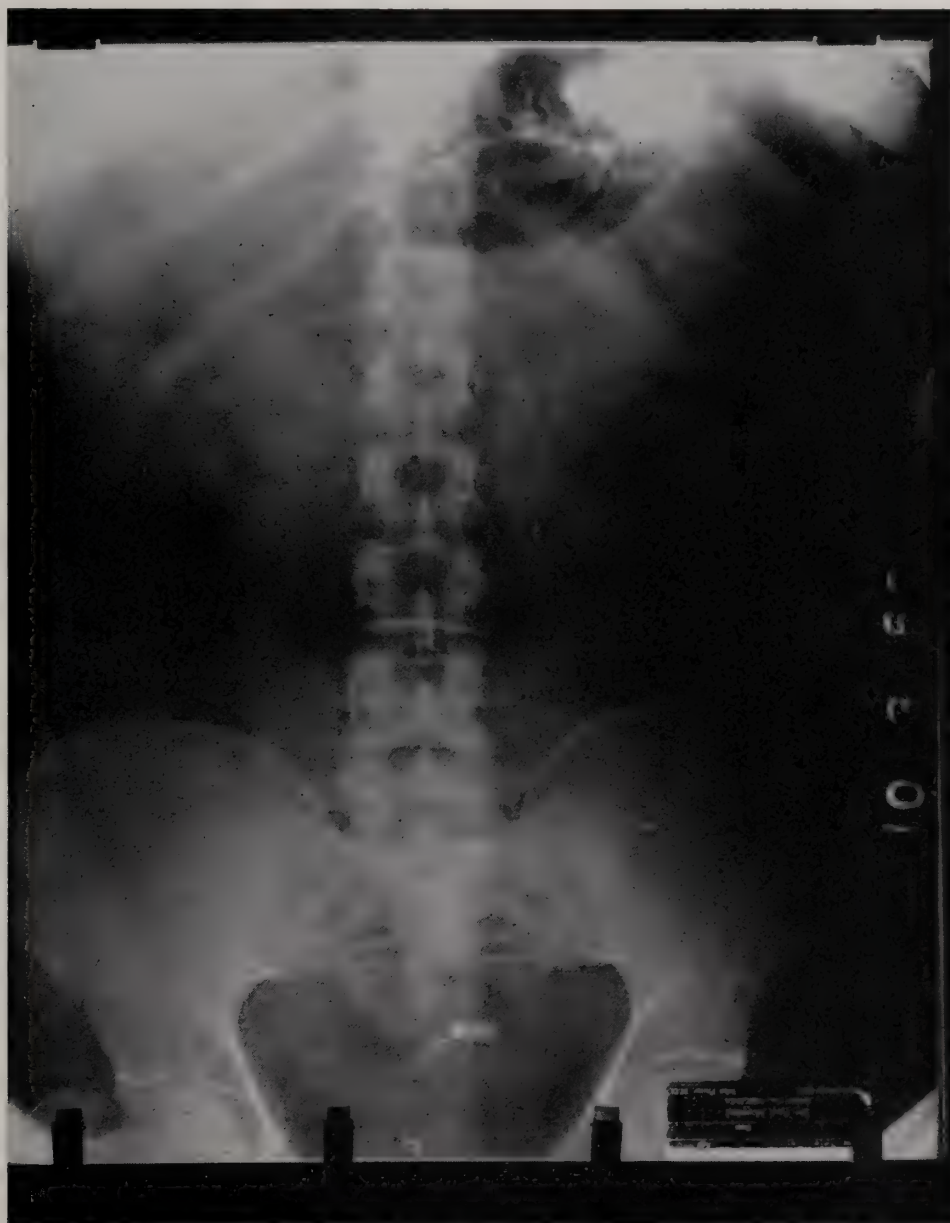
Plain Film of the Abdomen showing opaque material in the stomach and rectum.
